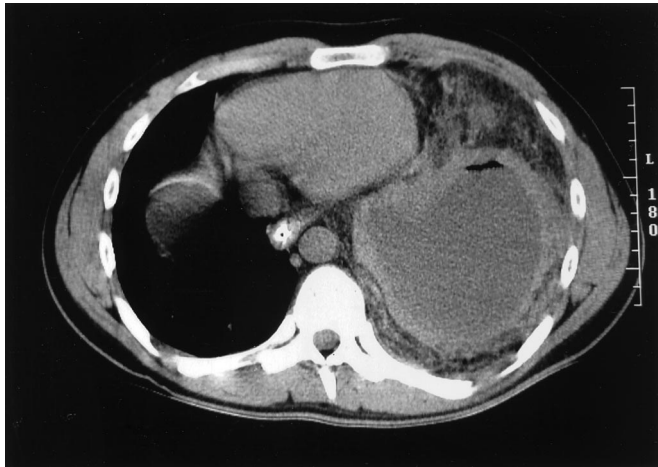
Abdominal CT scan. Pleural effusion on the left side with an intrathoracic fluid-and-air-containing, walled structure as well as a fat-containing structure compressing the ipsilateral lung and displacing the mediastinum to the right. The nasogastric tube is in place.
